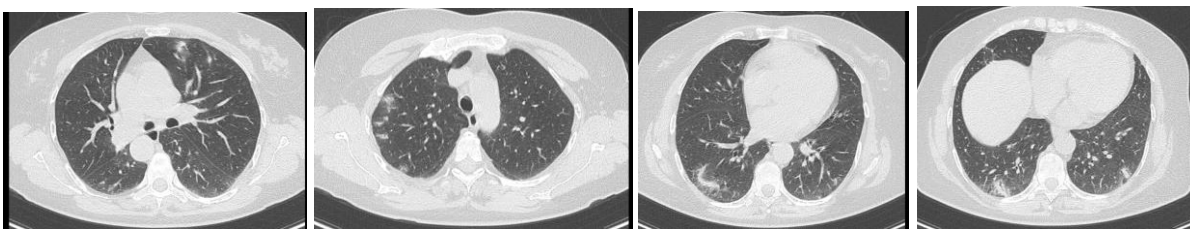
Chest CT scan showing partial regression of previously described bilateral, asymmetrical nodular and patchy ground-glass opacities.
